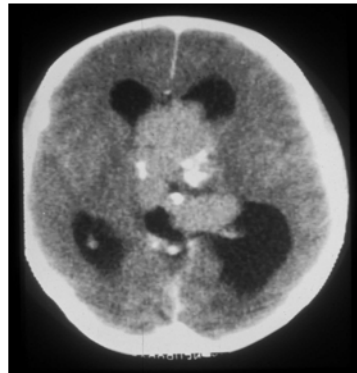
Enhanced CT appearance of an oligodendroglioma arising in the fornix. Calcification is prominent.
